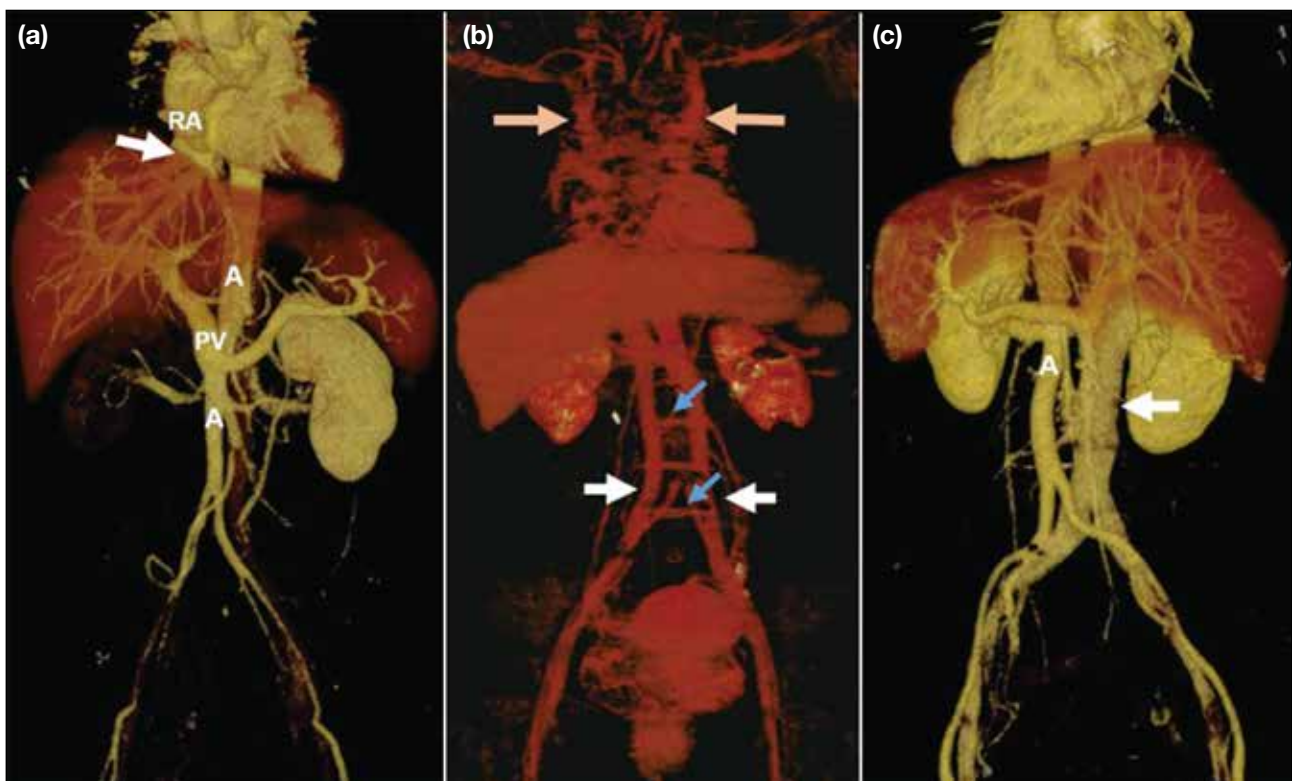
Volume-rendered contrast-enhanced computed tomography images. (a) Interrupted inferior vena cava (IVC) with absence of the infrahepatic IVC. The suprahepatic IVC (white arrow) drains into the right atrium (RA) of the heart. The normal portal vein (PV) and the aorta (A) are visible. (b) Rare case of complete duplication of the superior vena cava in the thorax (orange arrows) and the IVC in the abdomen (white arrows), with multiple bridging veins between duplicated segments (blue arrows). (c) The IVC (white arrow) lies to the left of the aorta (A), with dextrocardia in a patient with situs inversus totalis.
